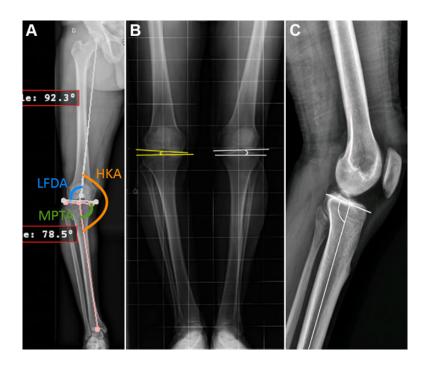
Measurements as shown on preoperative weightbearing long-leg and sagittal view radiographs. (A) Hip-knee-ankle angle (HKA), medial proximal tibial angle (MPTA), lateral distal femoral angle (LDFA). (B) Joint line convergence angle (in yellow), joint line obliquity (in white). (C) Posterior proximal tibial angle.
